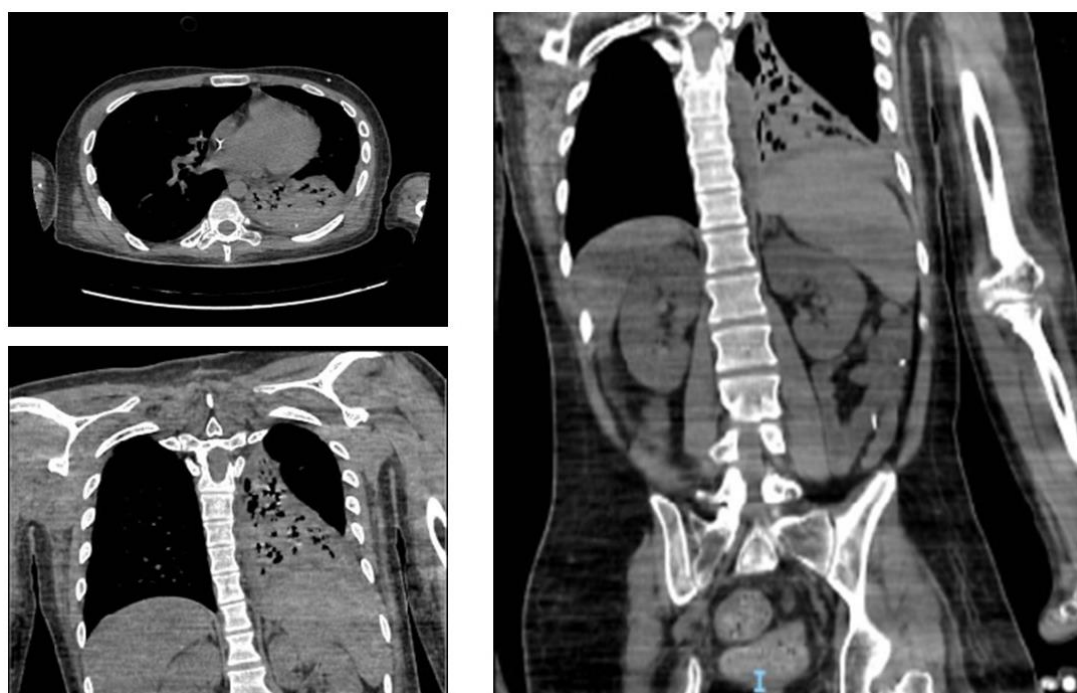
Results of the young patient's thoracic computerized tomography (CT) scan performed in case of fever resistant to paracetamol and ceftriaxone.
